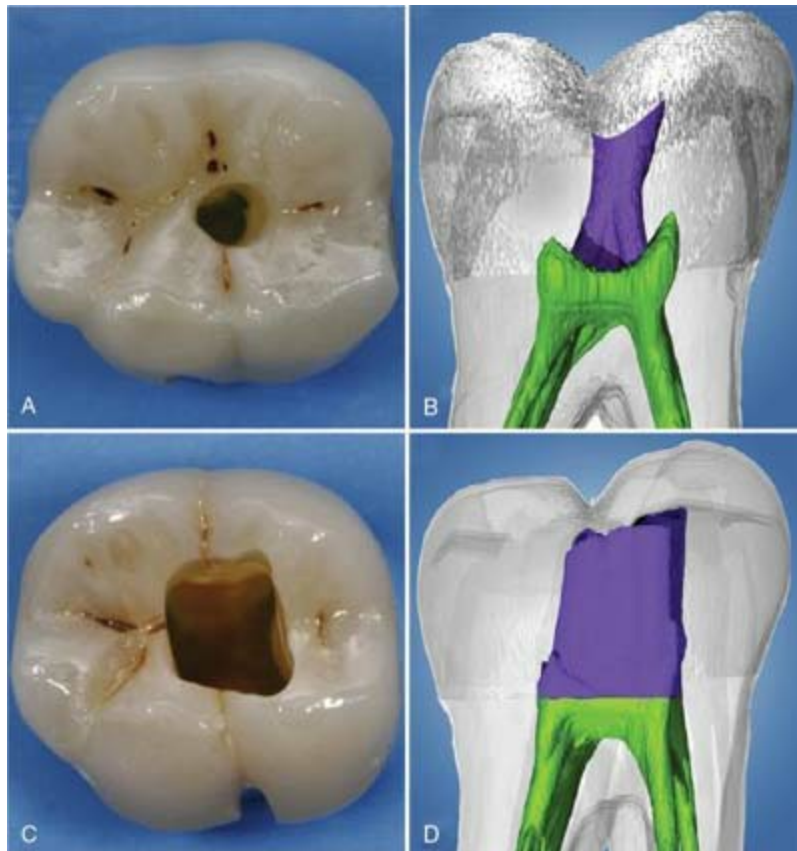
A, A photograph of a mandibular molar showing minimally invasive access cavity outline. B, A sagittal view of a μ CT reconstruction showing minimally invasive access cavity pathway. C, A photograph of a mandibular molar showing traditional access cavity
